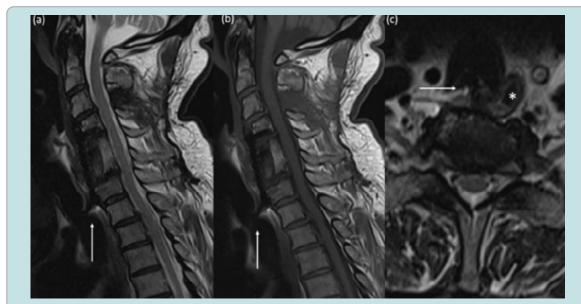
MRI. T2 sagittals (a) and T1 sagittals (b). The white arrow shows magnetic susceptibility artefact produced by the screw, impressing upon trachea. T2 axials (c) shows the screw impressing upon trachea while the adjacent collapsed oesophagus (asterix) is noted.
